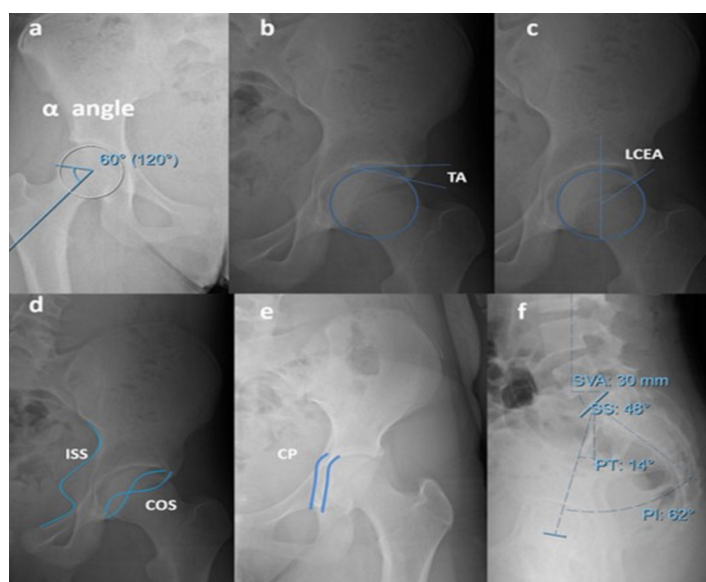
Radiographic measurements related to Femoroacetabular impingement morphology; a) Radiograph showing an example of alpha angle measurement on Antero-posterior pelvic imaging. b) Tönnis angle. c) Measurement of LCEA. d) Crossover sign and Ischial spine sign evaluation. e) The assessment of coxa profunda. f) The evaluation of Spino-pelvic parameters
